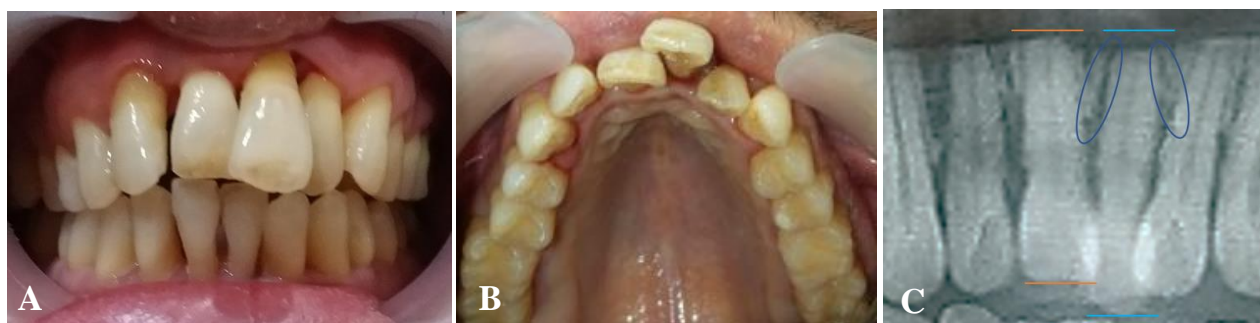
Pre-treatment intraoral facial view (A), upper occlusal view (B) and dental radiograph showed extruded left central incisor (blue lines) as compared with the neighbouring tooth (orange lines) (C).
